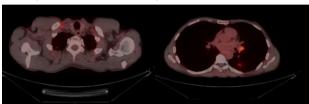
2nd presentation: Pet-CT showing right supraclavicular, left hilar lymphadenopathy, and left lower lobe nodule, all having positive uptake.
